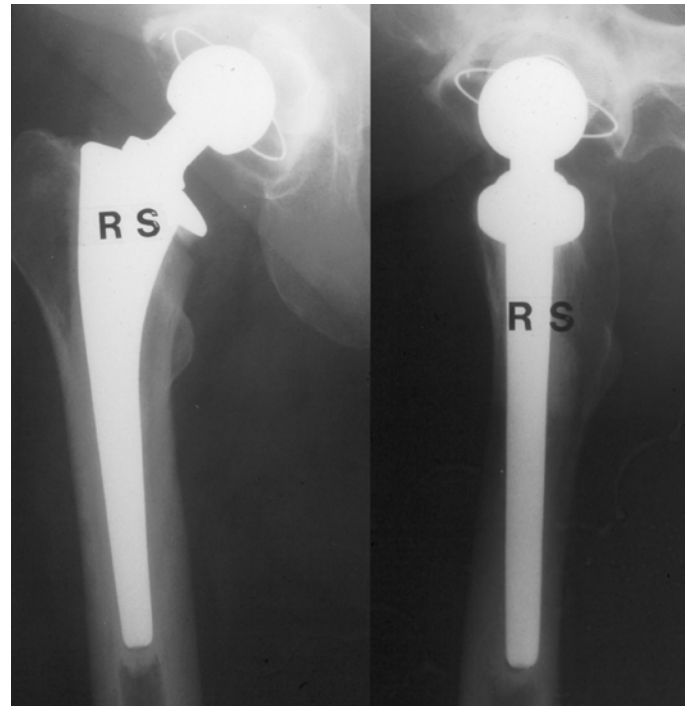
Post-op of R-120 A/P X-rays cemented in place, neck in position one slightly retroverted. (Courtesy Cameron)
